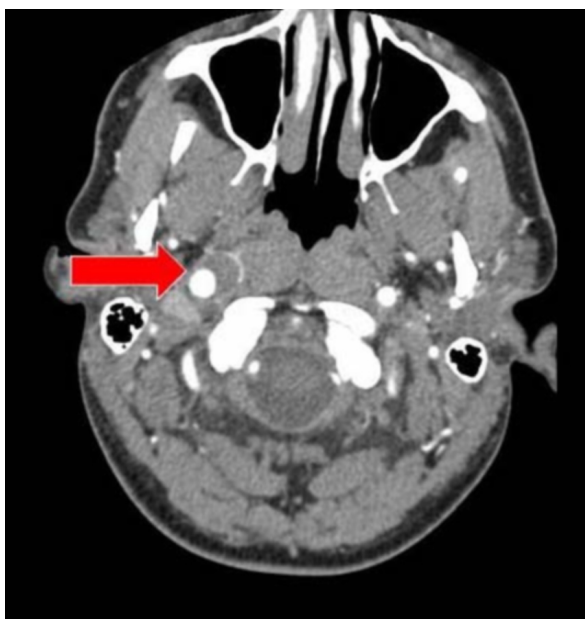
27-year-old man with Ehlers-Danlos syndrome, type IV. Axial CT with contrast of the head, highlighting dilated right internal carotid artery with a surrounding crescent of soft tissue density.
